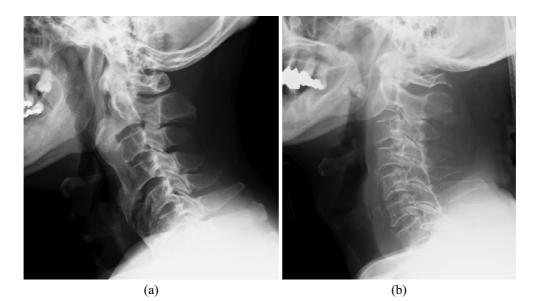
Representative cervical spine radiographs. (a) Ankylosis (+), (b) Ankylosis (–).
